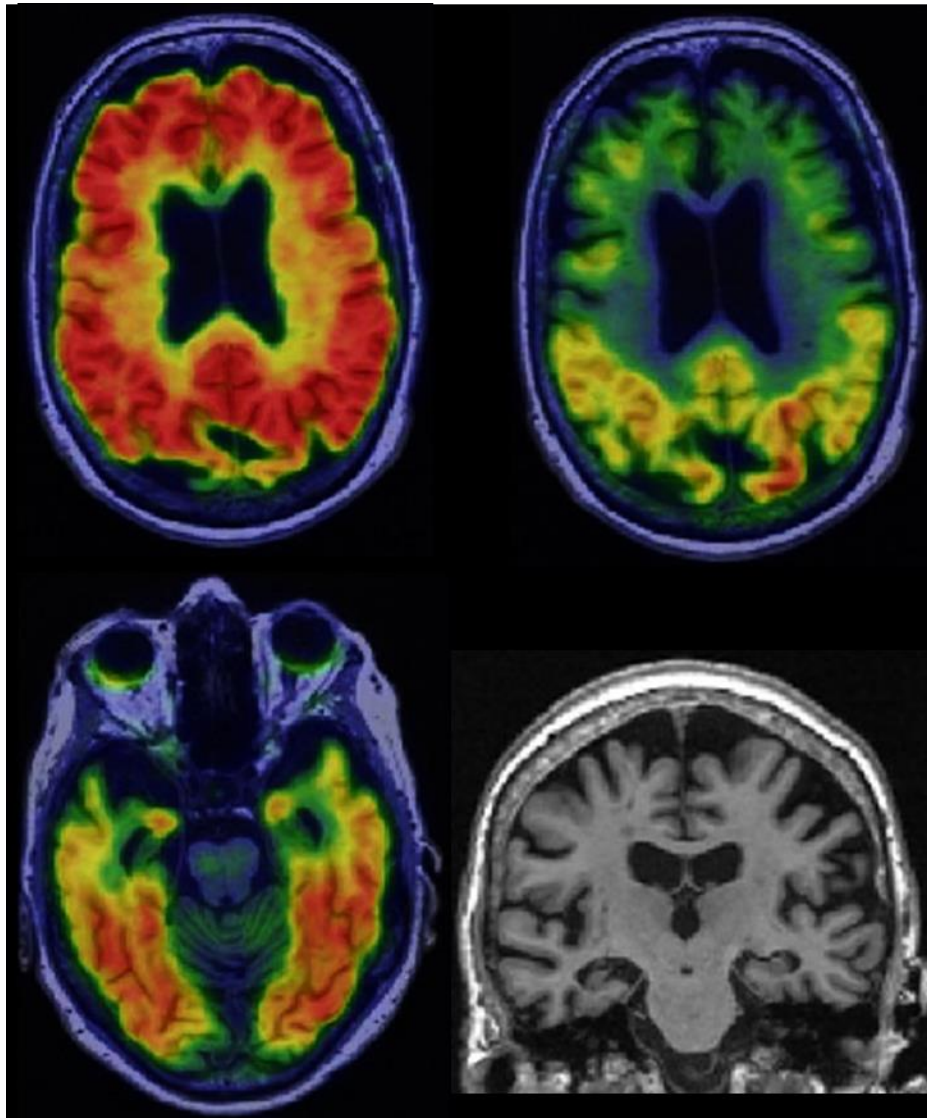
Alzheimer’s disease with dementia. 75 yo woman with amnesic multi domain dementia, abnormal amyloid PET (a), tau PET (b,c) and atrophy on MRI (d). Biomarker profile A+T+N+.
